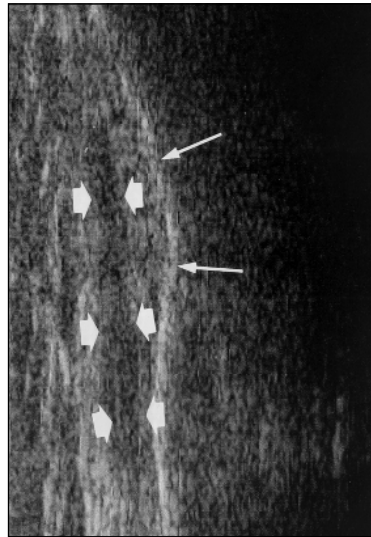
Coronal sonogram obtained in 34-year-old man through pes anserinus (short arrows) shows anteromedial tibial cortex (long arrows).
